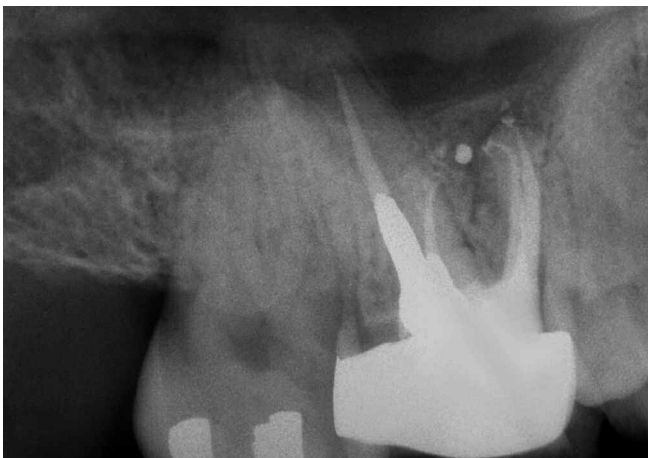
A distal angulated radiograph demonstrates the retreatment effort of the MB root. Note the identification and treatment of the MBII system.
